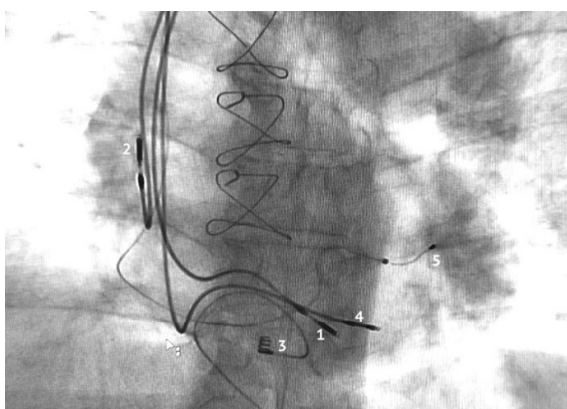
Final configuration of the CRT-P system. Follow-up chest x-ray demonstrating upgrade and positioning of all components: 1) new RV lead with active fixation; 2) RA lead; 3) old epicardial lead; 4) old RV lead, abandoned in situ due to high threshold of stimulation and capped off with silicon cap; 5) bipolar LV lead placed in the posterolateral venous branch
